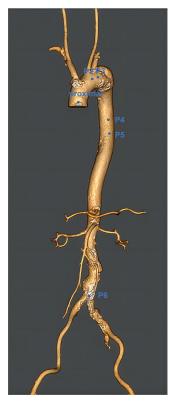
Preoperative computed tomography angiography (CTA) reconstruction image of one patient
